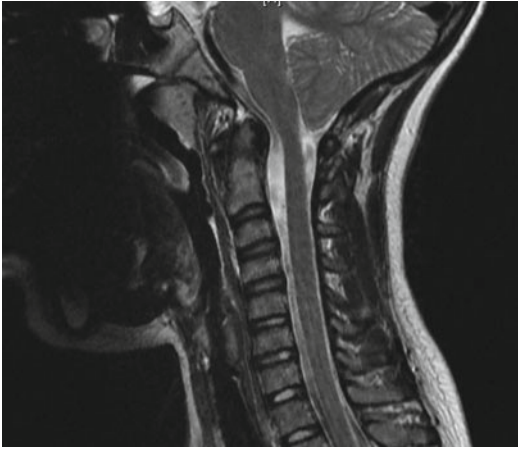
Sagittal T2W MRI image showing a typical Chiari 1 malformation. Cerebellar tonsils herniate below the level of the foramen magnum by more than 5 mm. CSF appears hyperintense; some isointense to brain parenchyma areas inside the subarachnoid space is CSF flow artifact. The presence of the CSF-filled subarachnoid space both ventrally and dorsally to the neural structures at the foramen magnum as well as the presence of CSF flow artifact suggest that this particular Chiari case is less likely to be symptomatic
